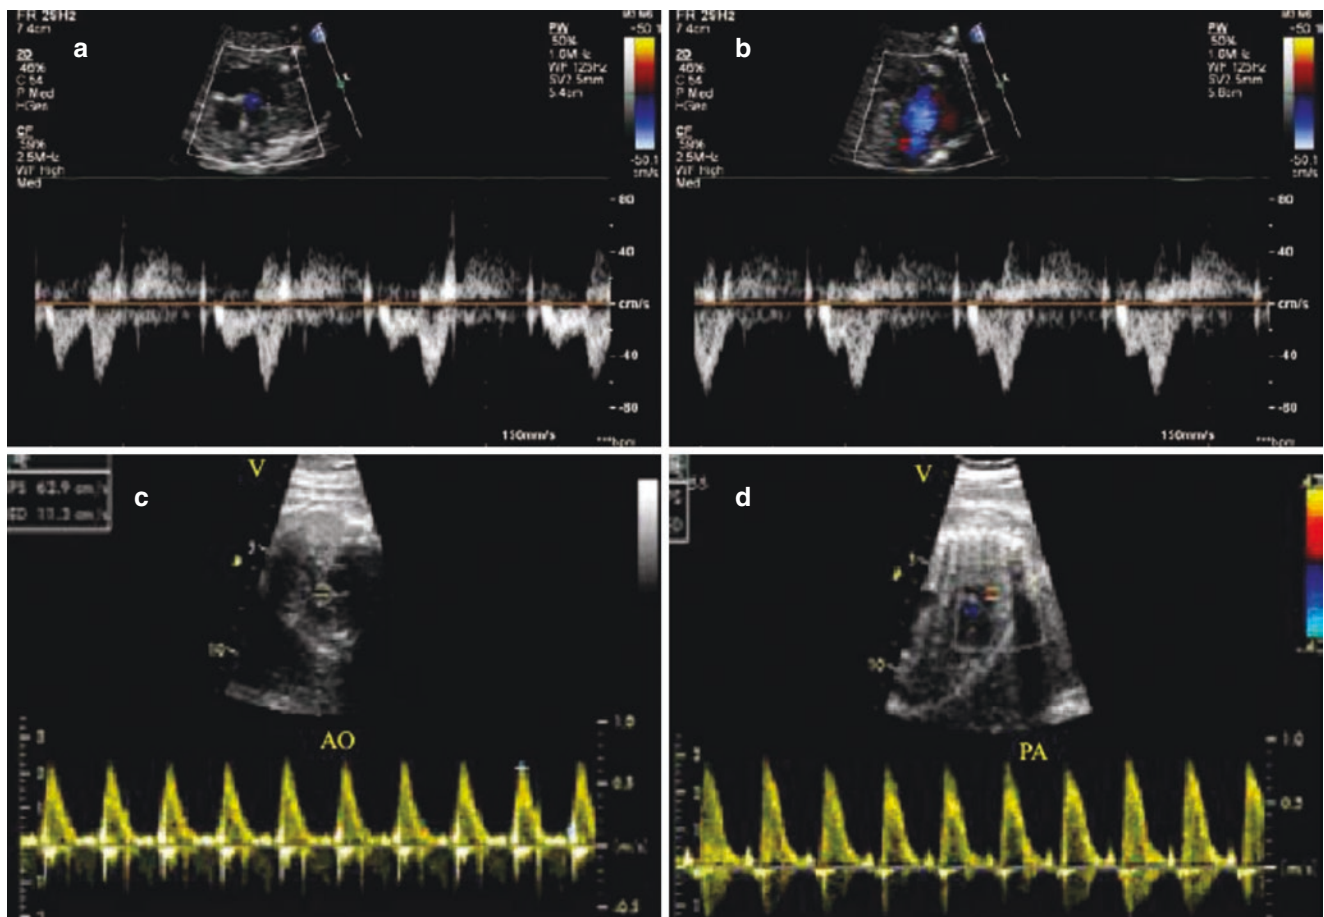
Doppler flow spectrum of the fetal heart. (a) Blood flow spectrum of the mitral valve orifice; (b) Blood flow spectrum of the tricuspid valve orifice; (c) Blood flow spectrum of the aortic valve; (d) Blood flow spectrum of the pulmonary valve
